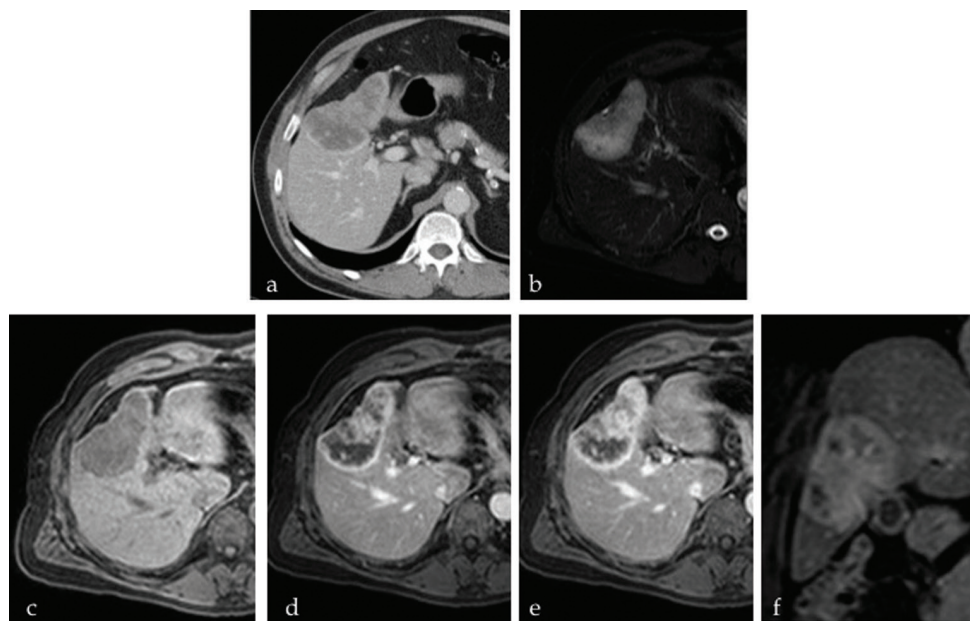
Intrahepatic cholangiocarcinoma. a. Computed tomography shows a lobulated mass with capsular retraction. b. T2W magnetic resonance imaging shows a hyperintense lesion. c–f. Pre- and post-contrast T1W magnetic resonance imaging shows continuous peripheral enhancement initially with centripetal filling.
